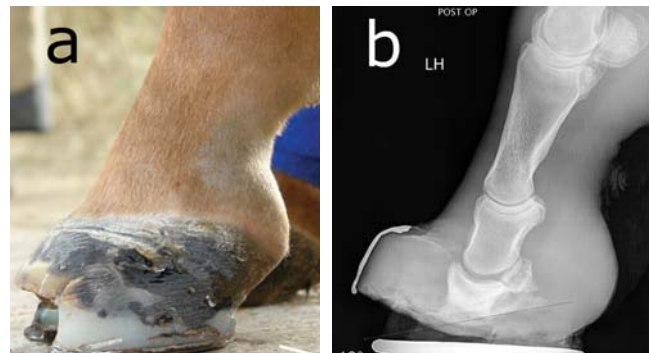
Gross examination (a) and latero medial radiograph (b) of the left rear foot after tenotomy of DDFT and realignment of the third phalanx.
